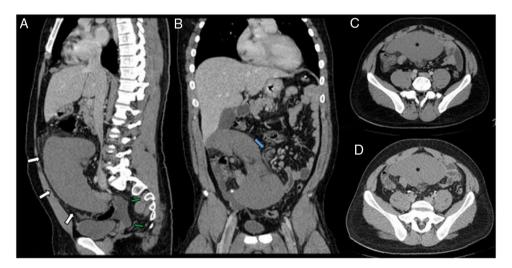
Contrast-enhanced abdominal CT in portal (A–C) and delayed (D) phases. Sagittal (A) and coronal (B) reformatting. Hypogastric mass corresponding to enlarged spleen. Inflammatory changes and peri-splenic fluid (green arrows) can be seen. In the coronal view, torsion of the splenic vessels with abnormal surrounding fat is shown (blue arrow). No significant differences in the enhancement pattern between the portal and delayed phases are observed (asterisk in C and D).
